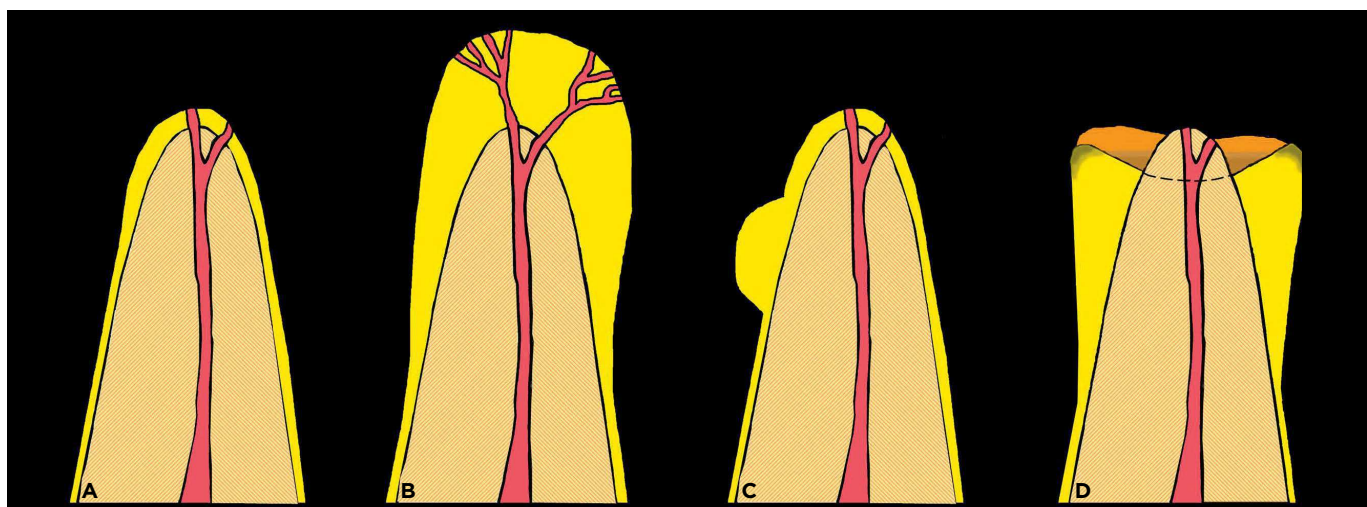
Morphological types of hypercementosis: A = normal root; B = club-shaped diffuse hypercementosis; C = focal or localized hypercementosis; D = hypercementosis in the shape of "shirt sleeve cuff", does not involve the most apical portion and occurs on the periphery as response to a chronic periapical lesion (Source: Pinheiro¹⁶).
